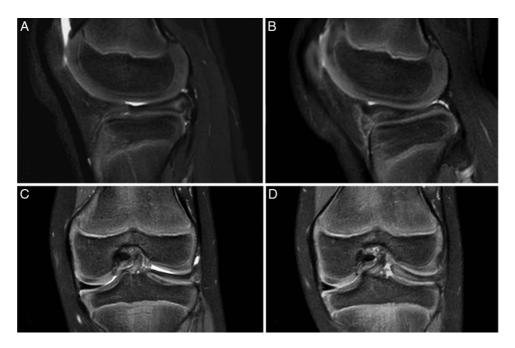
Case no. 1. MRI (T2 FS) sagittal (A and B) and coronal (C and D) acquisitions of a left knee during the dynamic protocol. Imaging reveals anterior and then posterior meniscal dislocation, respectively, after the "clock" (A and C) and after the "pop" (B and D). Arthroscopy confirmed a complete peripheral meniscal detachment (type C, according to Ahn). A, MRI (T2 FS, sagittal) performed after the "clock," showing posterior displacement of the lateral discoid meniscus (LDM). B, MRI (T2 FS, sagittal) performed after the "pop," showing anterior displacement of the LDM. C, MRI (T2 FS, coronal) performed after the "clock," showing the LDM without displacement in the frontal plane. D, MRI (T2 FS, coronal) performed after the "pop," showing medial displacement of the LDM. FS indicates Fat-Sat; MRI, magnetic resonance imaging.
